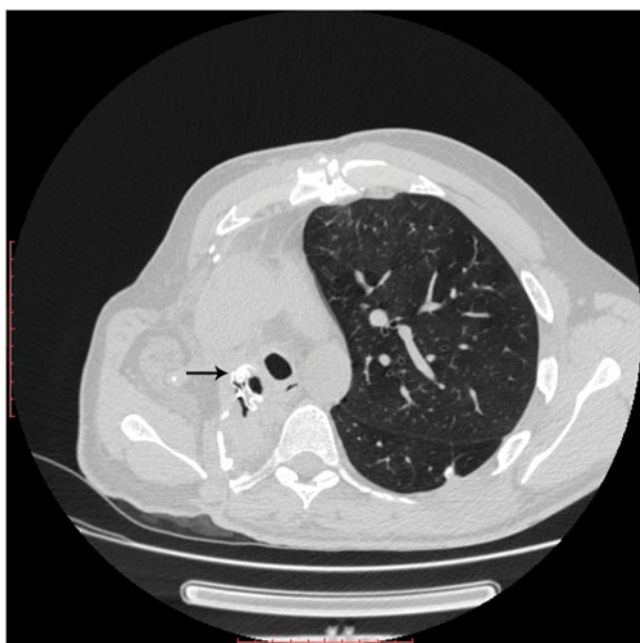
Patient no. 2 in Table 1. Computed tomography scan 1 year after the installation of the occluder. Arrow points to the occluder.
